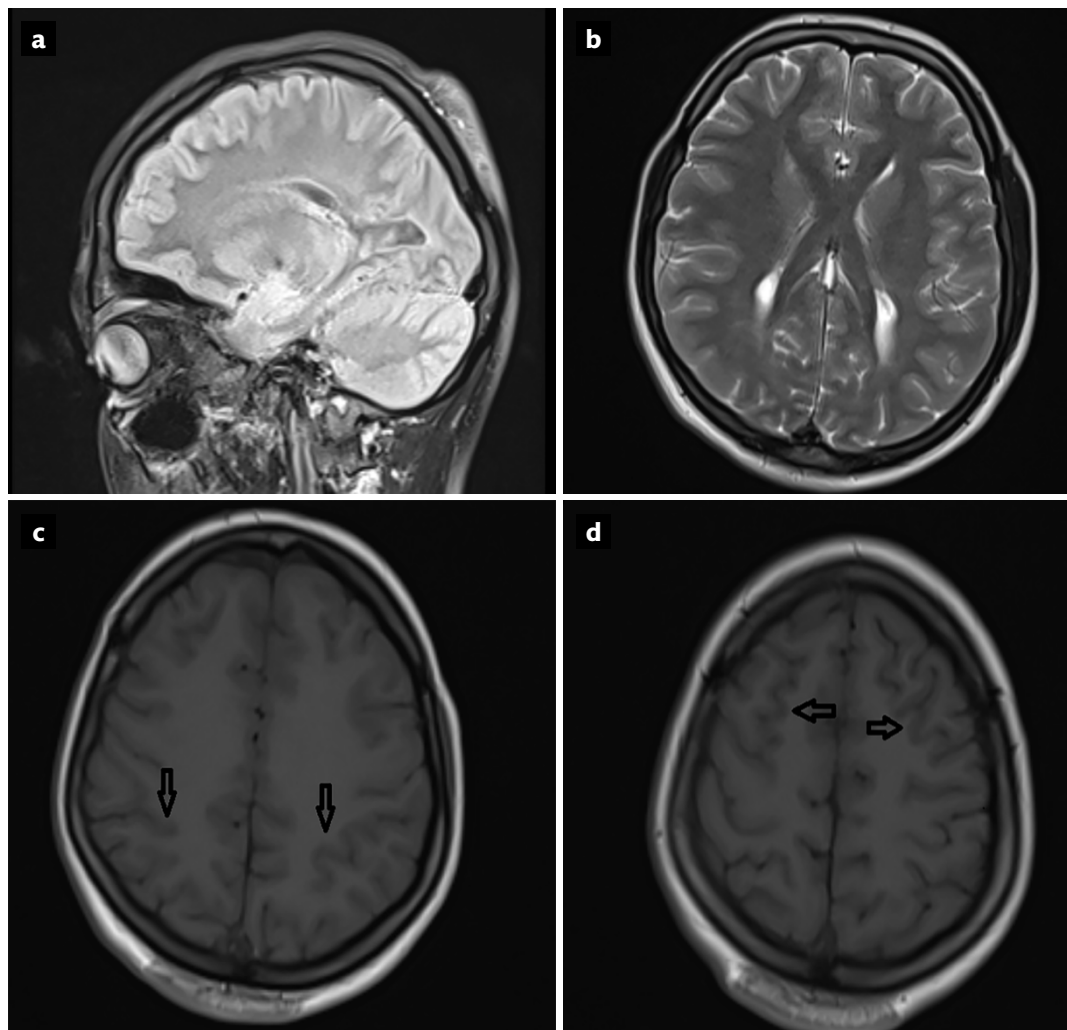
MRI imaging of the patient's structural brain abnormalities.
